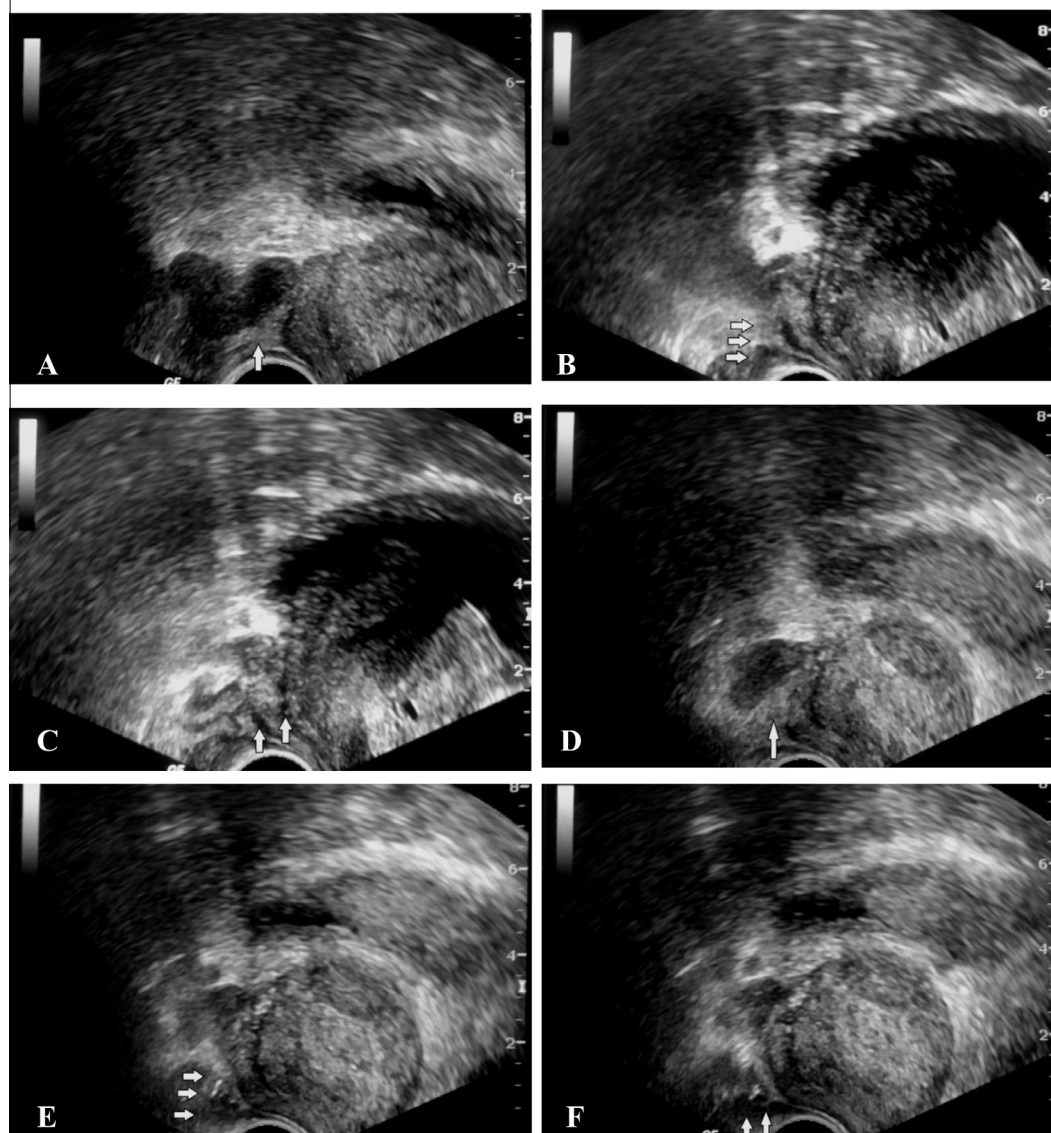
65-Year old male patient with senile enlargement of the prostate referred to us for TRUS guided biopsy due to elevated PSA (5 ng/ml). Starting with the right side, sagittal ultrasound view (A) shows white pyramidal site between the prostate and the seminal vesicle laterally “Mount Everest sign” (arrow). The 22-gauge, 7-inch spinal needle placed through the biopsy guide channel under ultrasound guidance (B) into the area where the prostatic innervations enter (arrows) followed by injection of 10 ml lidocaine. The ultrasonic wheal (arrows) is seen as a hypoechoic filling of the Mount Everest site (C) dissecting along the nerve to bathe the entire ipsilateral prostatic innervation. The same steps are repeated on the left side (D–F).
